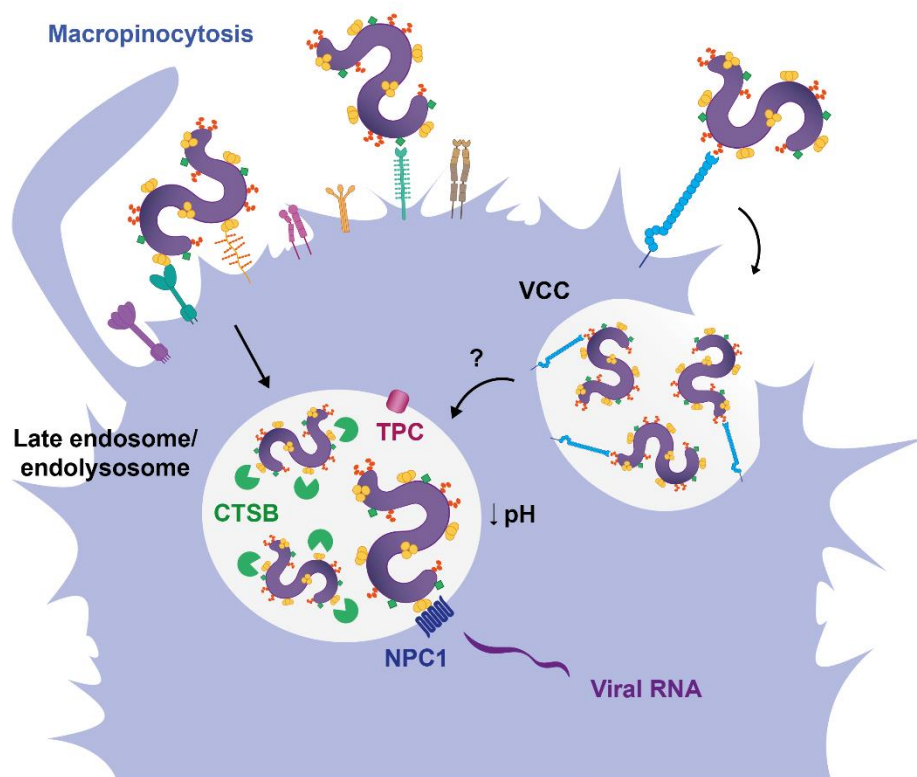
Siglec-1 is an attachment factor mediating EBOV entry into myeloid cells. A. Viral attachment via glycoprotein-dependent, glycoprotein-independent or unidentified mechanisms. B. Viral internalization begins when viruses enter early endosomes through macropinocytosis. Viral cargo of early endosomes is transferred to late endosomes, where CT SB cleaves viral glycoprotein to allow for NPC1 interaction and viral RNA entry into the cytoplasm. Viral particles captured by Siglec-1 are directed towards a VCC, that eventually converges with the endosome trafficking pathway through an unidentified mechanism. VCC: virus-containing-compartment; TPC: two-pore channel; CT SB: cathepsin B; NPC1: Niemann-Pick receptor C1. From ref.²⁸⁹.
